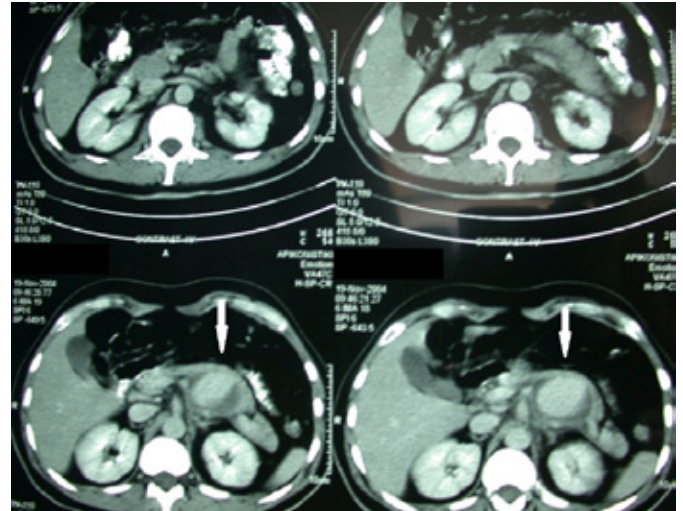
Computed tomography angiography (CTA) of case 3 showing a large pseudoaneurysm of the splenic artery (arrows).
